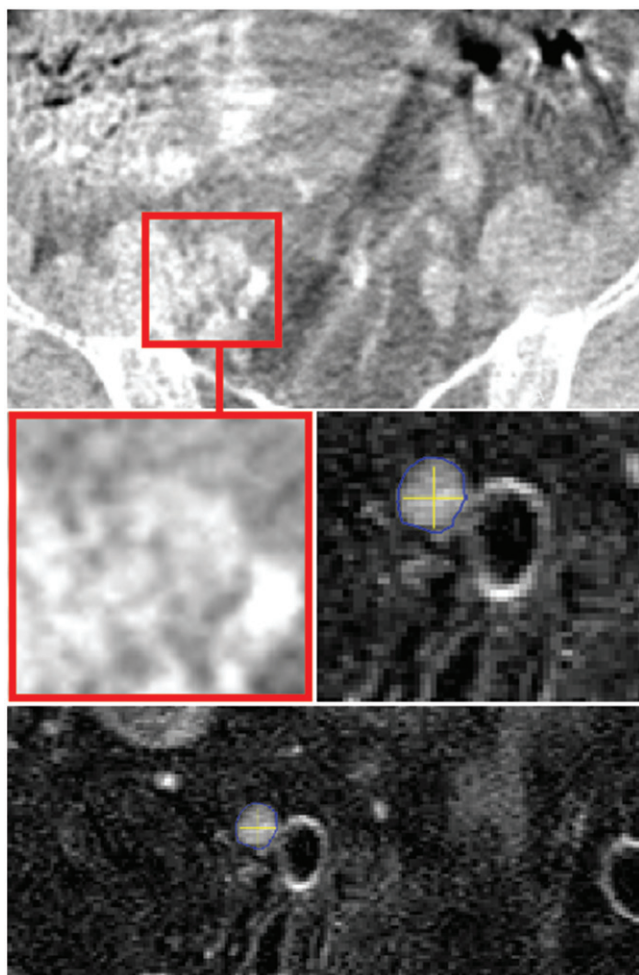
Transversal CBCT image (top and left) and a transversal T2-weighted mDIXON water image (bottom and right) of the same patient. The lymph node in the left iliac region is poorly visible on the CBCT and would therefore be treated with an 8 mm PTV margin to sufficiently incorporate uncertainties, especially position verification.
